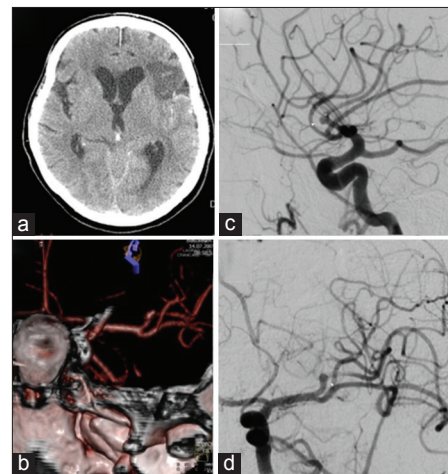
(a) Native multislice computed tomography showing left-side fronto-opercular cerebral ischemia and subarachnoid hemorrhage. (b) Multislice computed tomography angiography showing an aneurysm on the left M2 middle cerebral artery branch 5 mm from the M1 middle cerebral artery branch bifurcation. Digital subtraction angiography, lateral (c) and anteroposterior (d) view showing an M2 branch bifurcation aneurysm, absence of blood flow in the “smaller” frontal opercular M3 segment implying thrombosis and filiform blood flow in the “larger” insular M3 segment resembling partial vessel thrombosis
